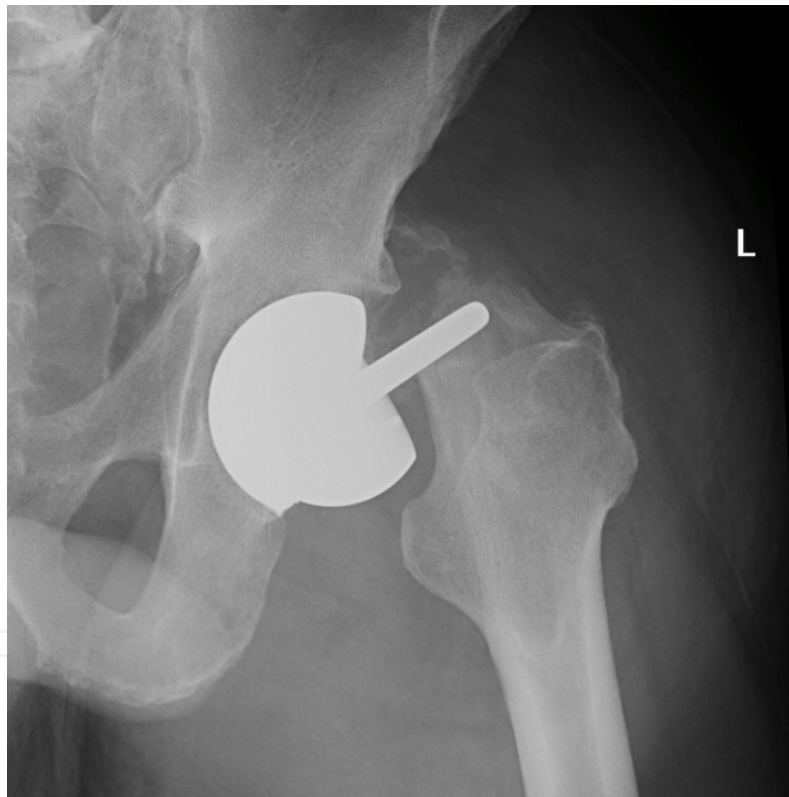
X-ray of a femoral neck fracture following hip resurfacing arthroplasty
